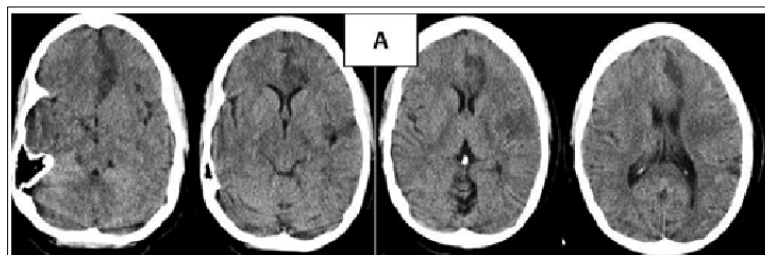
A CT scan demonstrated an acute infarct of the left MCA and ACA at 36 hours.
